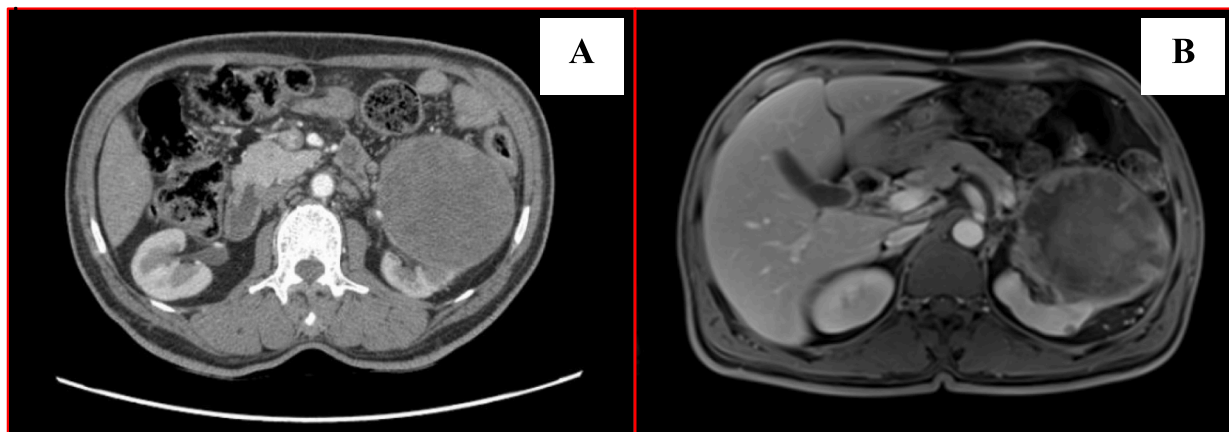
(A) CT with contrast revealed a large well-defined lesion in inter-polar region of left kidney and (B) MRI indicated the renal lesion with renal cell carcinoma.
